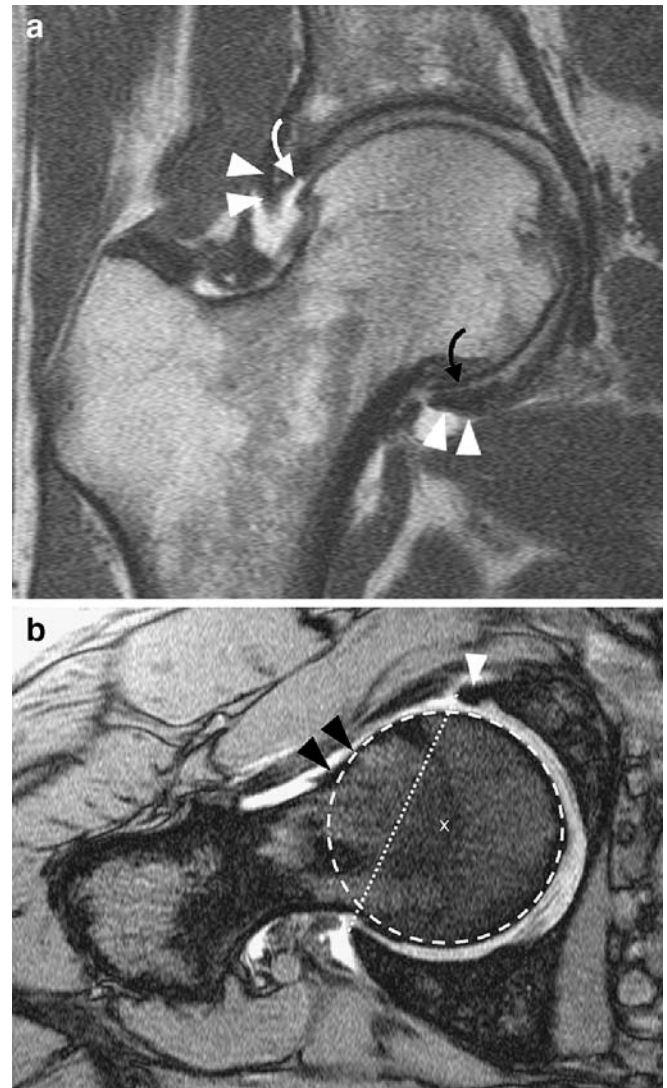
Pincer-type of femoroacetabular impingement (FAI). a On the coronal T1-weighted spin echo image (MR arthrogram) protrusion of the femoral head is seen. The labrum is partially ossified at the base (white arrows) and cartilage defects are visible anterosuperiorly (white curved arrow) and posteroinferiorly (black curved arrow). b On the angled axial gradient echo sequences a normal offset of the head-neck junction (black arrowheads) is visible. Overcoverage of the femoral head is present when the center of the circumference of the head (x) is behind the line (dotted line) drawn from the anterior labrum (white arrowhead) to the posterior labrum
